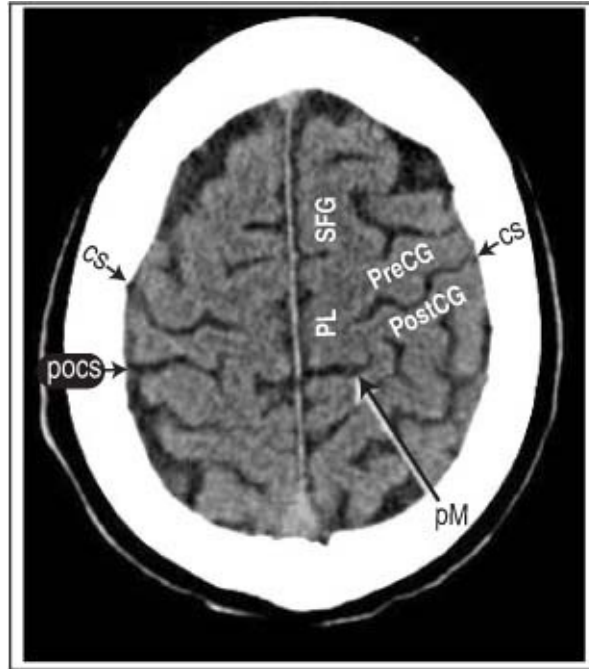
CT scan (upper cut) showing gyri/sulci. See [Table 5-1](#) and [Table 5-2](#) for abbreviations
